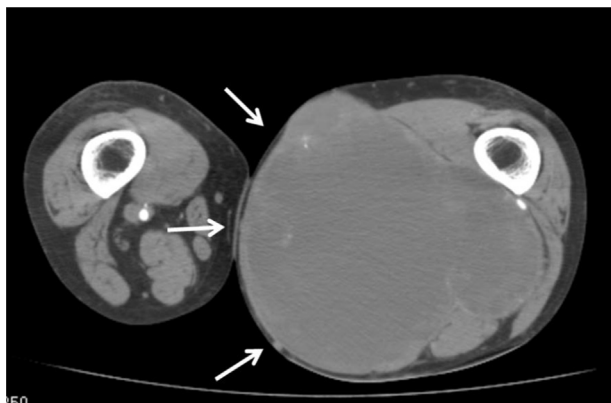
Contrast-enhanced computed tomography (CT) imaging. Axial CT image revealed a 15 × 14 × 13-cm soft tissue mass, suggesting a homogeneous tumor without calcification. A mild contrast was identified at the wall of the tumor (arrow).
